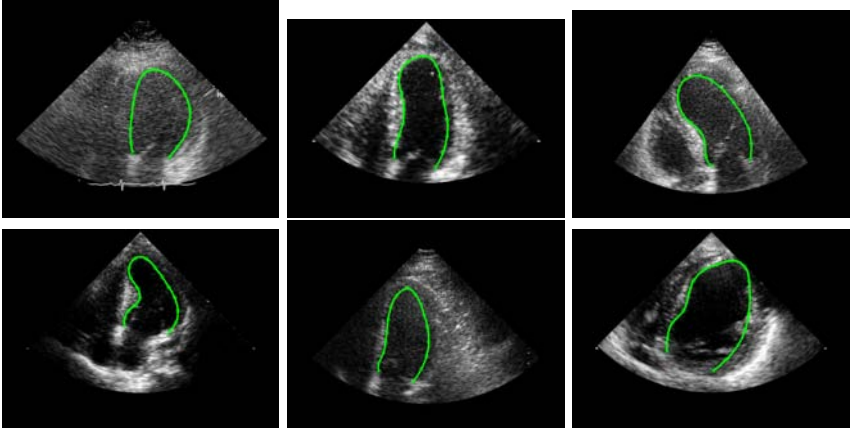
Examples of A4C echocardiogram. The expert annotation of the LV endocardium is marked by the green line. The shape is represented by 17 landmarks and the cubic spline is used for interpolation.
